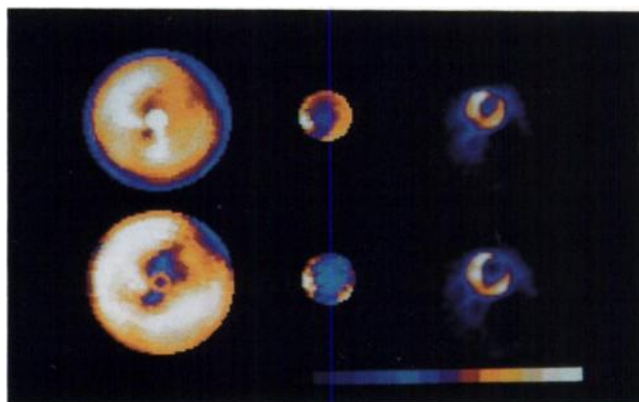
Ungated acquisition. This figure compares the bull's-eye images (left column), CAP displays (middle column) and corresponding transaxial slices (right column) from one subject. (Top row) Baseline-rest images were acquired during normal segmental contraction. (Bottom row) Occlusion images were acquired during abnormal segmental contraction. Abnormal segmental contraction per se caused an apparent "perfusion" defect on ungated SPECT myocardial perfusion images.
